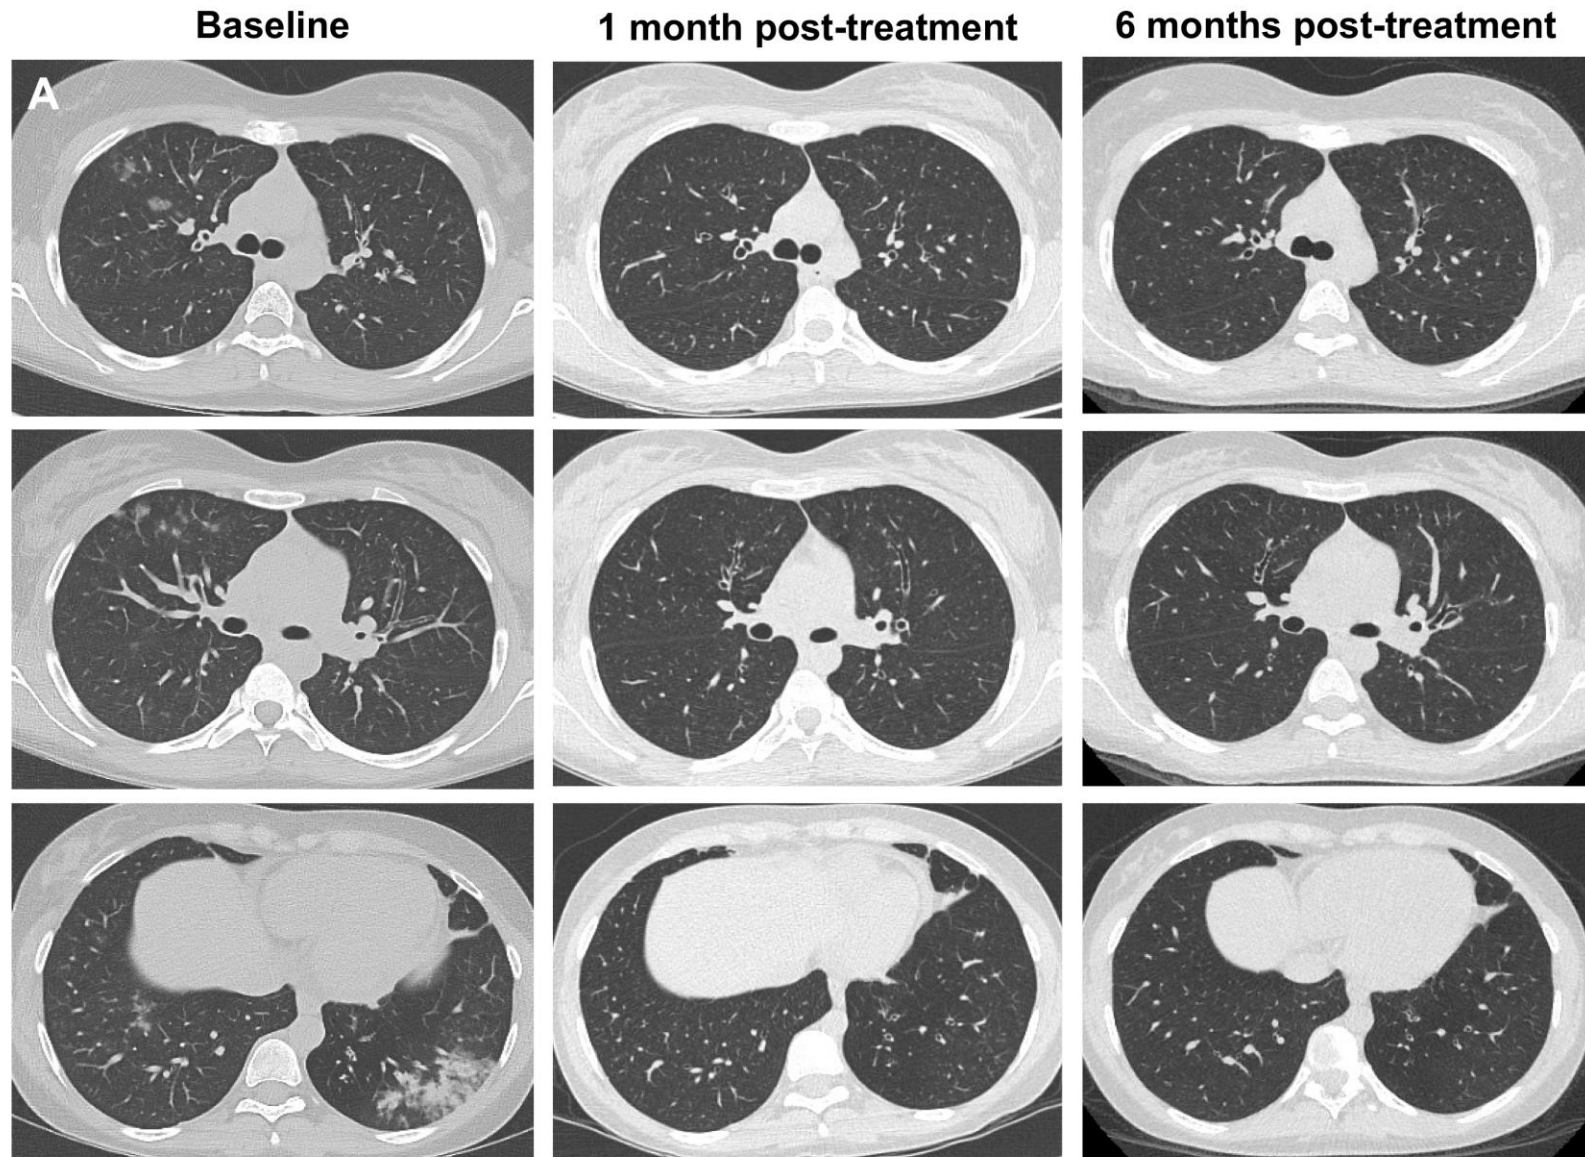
Treatment response assessed by radiography in patient 2. Shown are serial axial (A) and coronal (B) chest CT images and coronal 3D reconstructed CT images (C) at baseline and at 1 and 6 months after treatment initiation.
